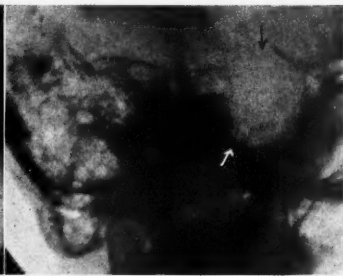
Roentgenogram of the temporal bone after the Stenvers method. Destruction of the apex of the pyramid as caused by an endothelioma.
